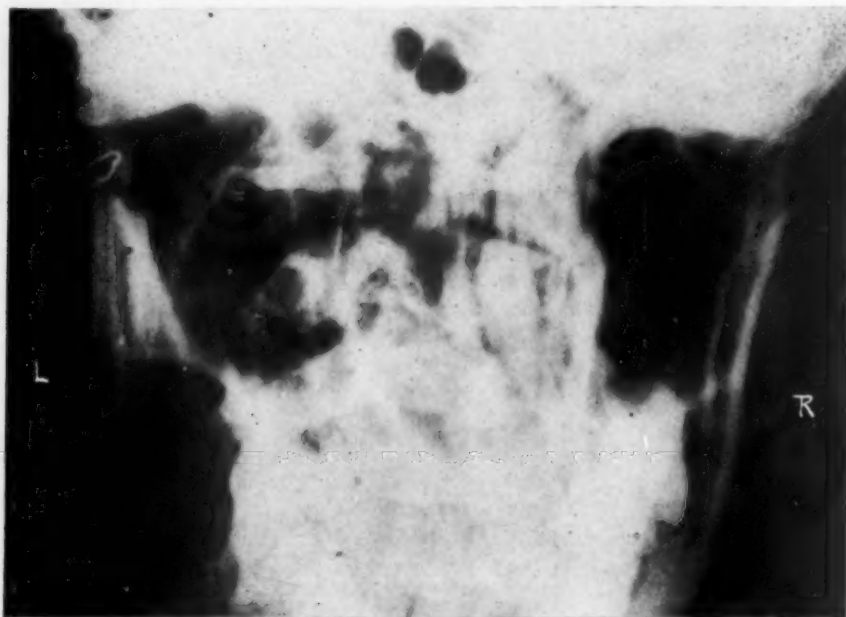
Anteroposterior x-ray showing internal wiring fixation on the left, condylectomy on the right.
